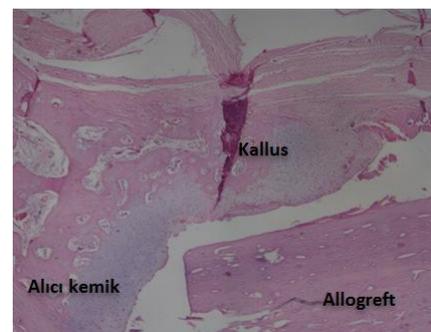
Low intensity pulsatile ultrasound application
